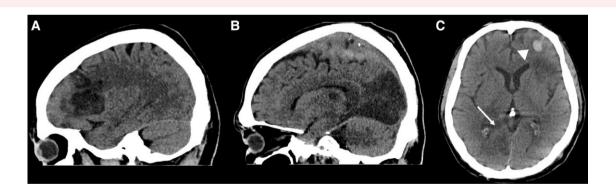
Computed tomography scan showed ischaemic infarcts in the left middle cerebral artery (A) and right posterior cerebral artery (B); as well as a left frontal lobe haemorrhage (C, arrowhead) and an incipient haemorrhagic transformation of the posterior cerebral artery stroke (C, arrow).
